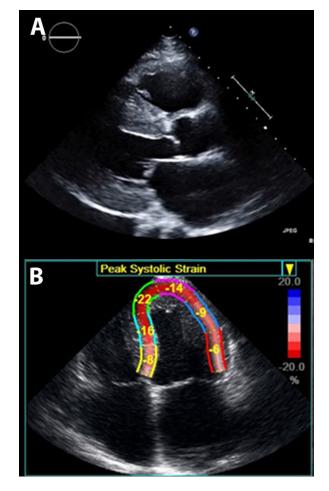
Echocardiogram in cardiac amyloidosis. Panel A shows increased wall thickness of the left ventricle and the bright and sparkly myocardium. Panel B shows that the function of the heart measured as peak systolic strain is better preserved at the apex compared to the base (-22 vs - 8, -14 vs - 6). These two features as well as relaxation abnormalities (not shown) are commonly seen in cardiac amyloidosis.
